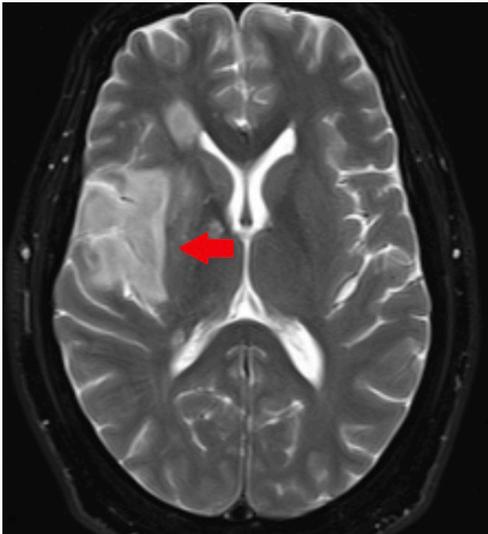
Axial section of MRI brain revealing acute right middle cerebral artery infarct.
